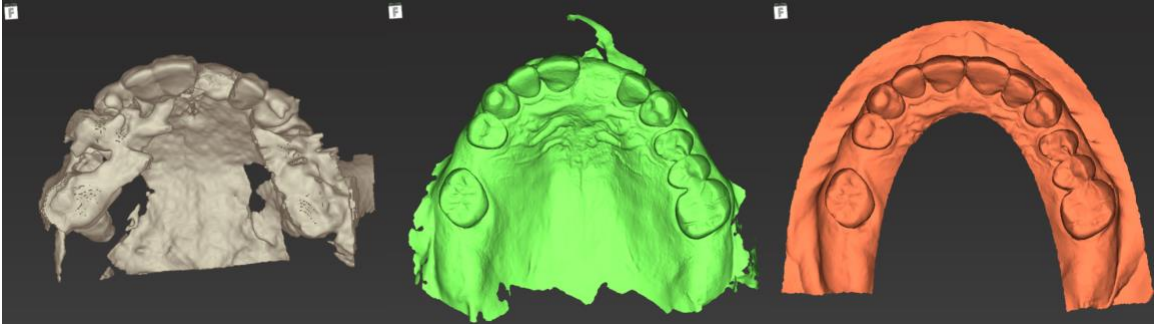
Preparing of patient's preoperative CBCT scan image (DICOM), preoperative intraoral scanned image (STL) and wax-up cast scanned image (STL)
